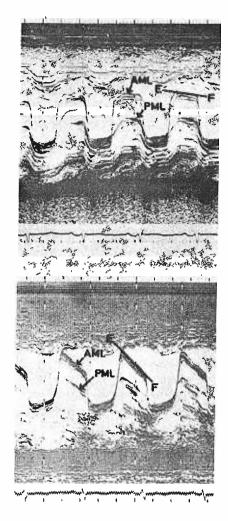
Top panel — Echocardiogram of a patient with severe mitral stenosis before mitral valvotomy. aml = anterior leaflet of mitral valve. pml = posterior leaflet of mitral valve. Bottom panel — After mitral valvotomy (see text)
